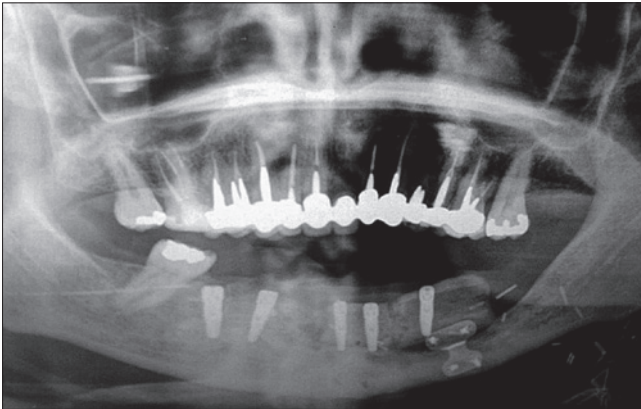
Rx orthopantomographic image after implant positioning.
